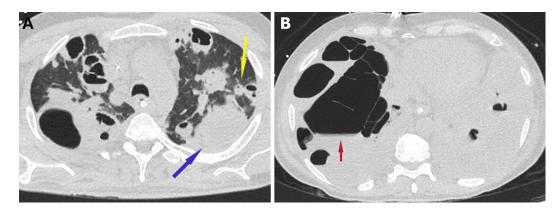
(A, B) Computed tomographic chest imaging without contrast showing extensive bilateral cavitary nodules and consolidations (*yellow arrow*), with a large right loculated hydropneumothorax (*red arrow*) and large left loculated pleural effusion (*blue arrow*).
